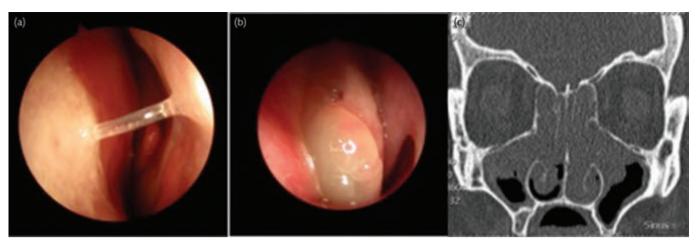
(a) An endoscopic view of the left nasal cavity in a patient with allergic rhinitis. Note the pale colour of the nasal septum and turbinate in addition to the clear secretions. (b) An endoscopic view of nasal polyps in the left nasal cavity. Polyps have glistening greyish colour in contrast to the red colour of the turbinate and rest of the nasal mucosa. (c) A coronal CT section of the nasal cavity and sinuses showing extensive opacification in a patient with severe chronic rhinosinusitis.
